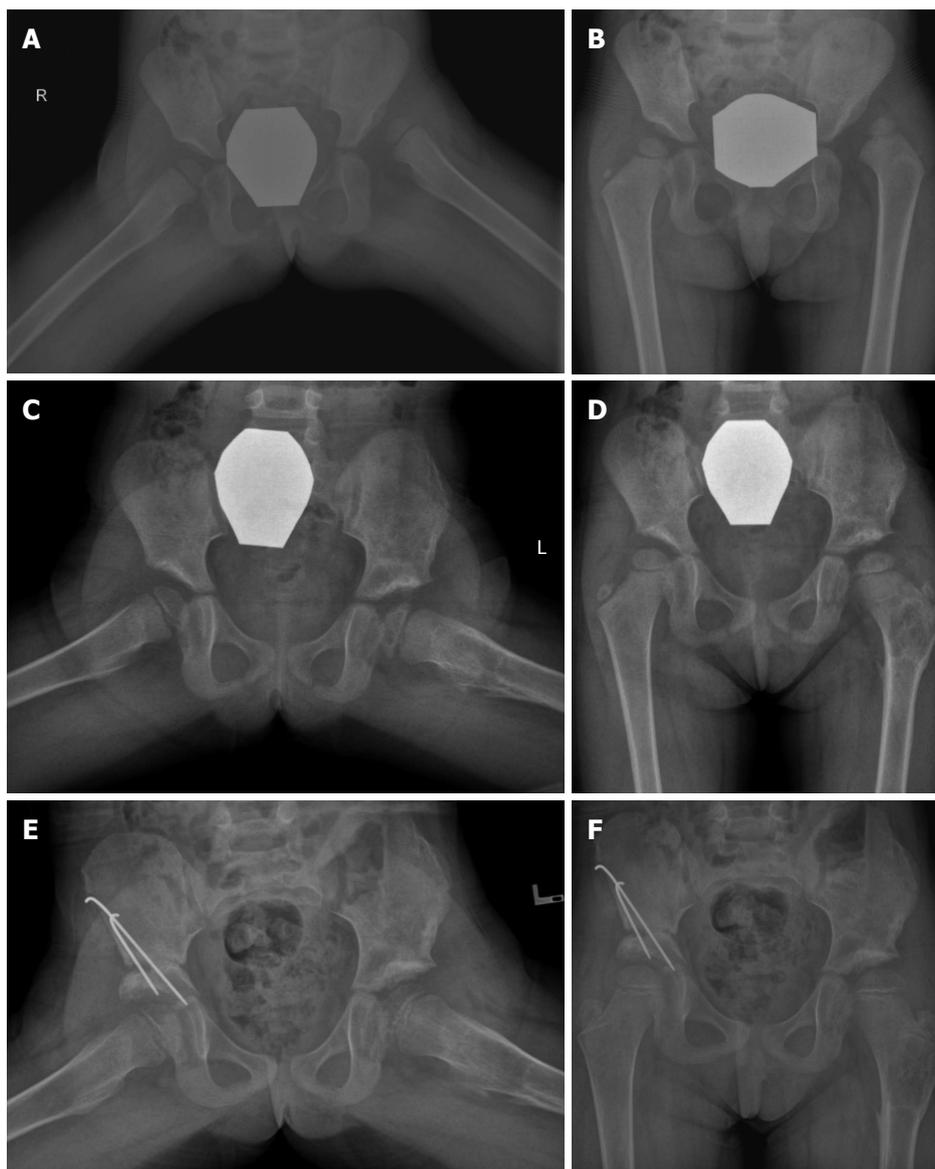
Hip reconstruction. A, B: Female patient, diagnosed with bilateral developmental dysplasia of the hip at the age of 2.5 years; C, D: On presentation left hip reconstruction, that included open reduction, Salter osteotomy and femoral derotational osteotomy with shortening, was performed. Post-operative X-rays after removal of the internal fixation devices are shown; E, F: Due to persistent mild hip dysplasia on the right side, a Salter osteotomy was performed at the age of 4 years.
